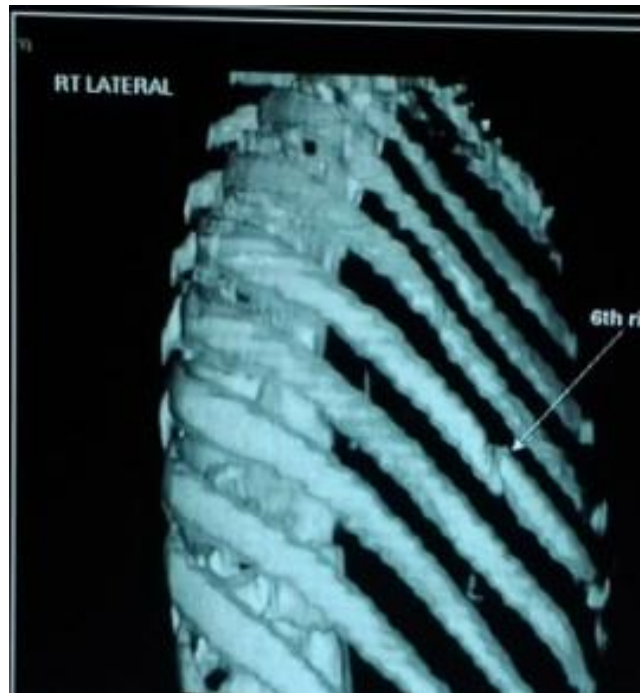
Reconstruction CT of the thorax. The arrow marks the fractured sixth rib.
